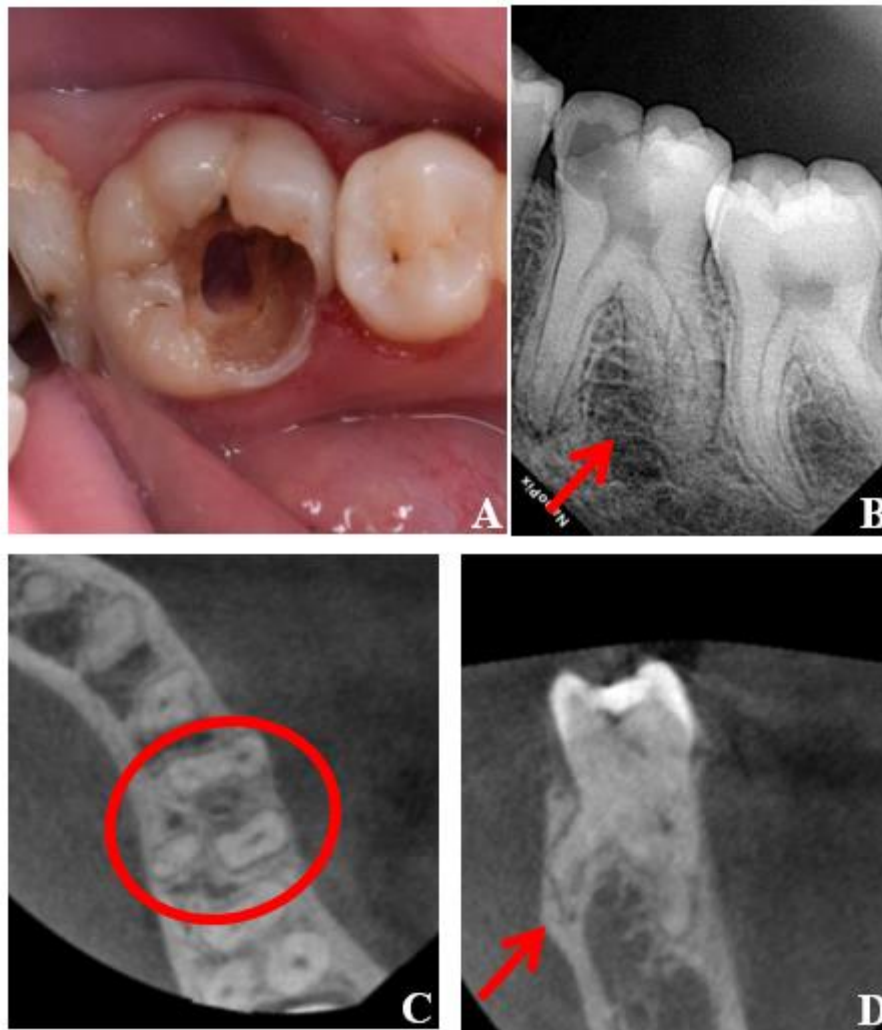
(A) Initial clinical photograph of tooth 36 showing extensive carious lesion involving the pulp chamber. (B) Periapical radiograph of tooth 36 demonstrating radiolucency reaching the pulp and suspected additional root (red arrow). (C) CBCT axial view confirming the presence of a radix entomolaris (red circle). (D) CBCT sagittal view showing the independent distolingual root canal corresponding to the radix entomolaris (red arrow).
